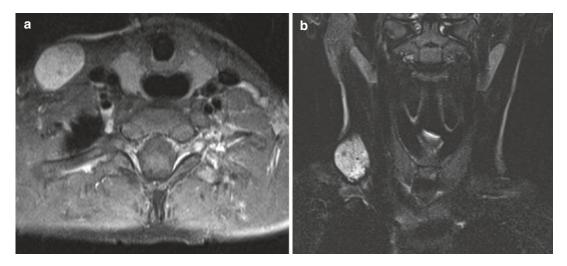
Infantile hemangioma in a 4-year-old boy. (a) Coronal FS T2-weighted image shows a soft tissue mass on the right side of the neck. (b) Axial CE T1-weighted image shows marked homogeneous enhancement of the mass
